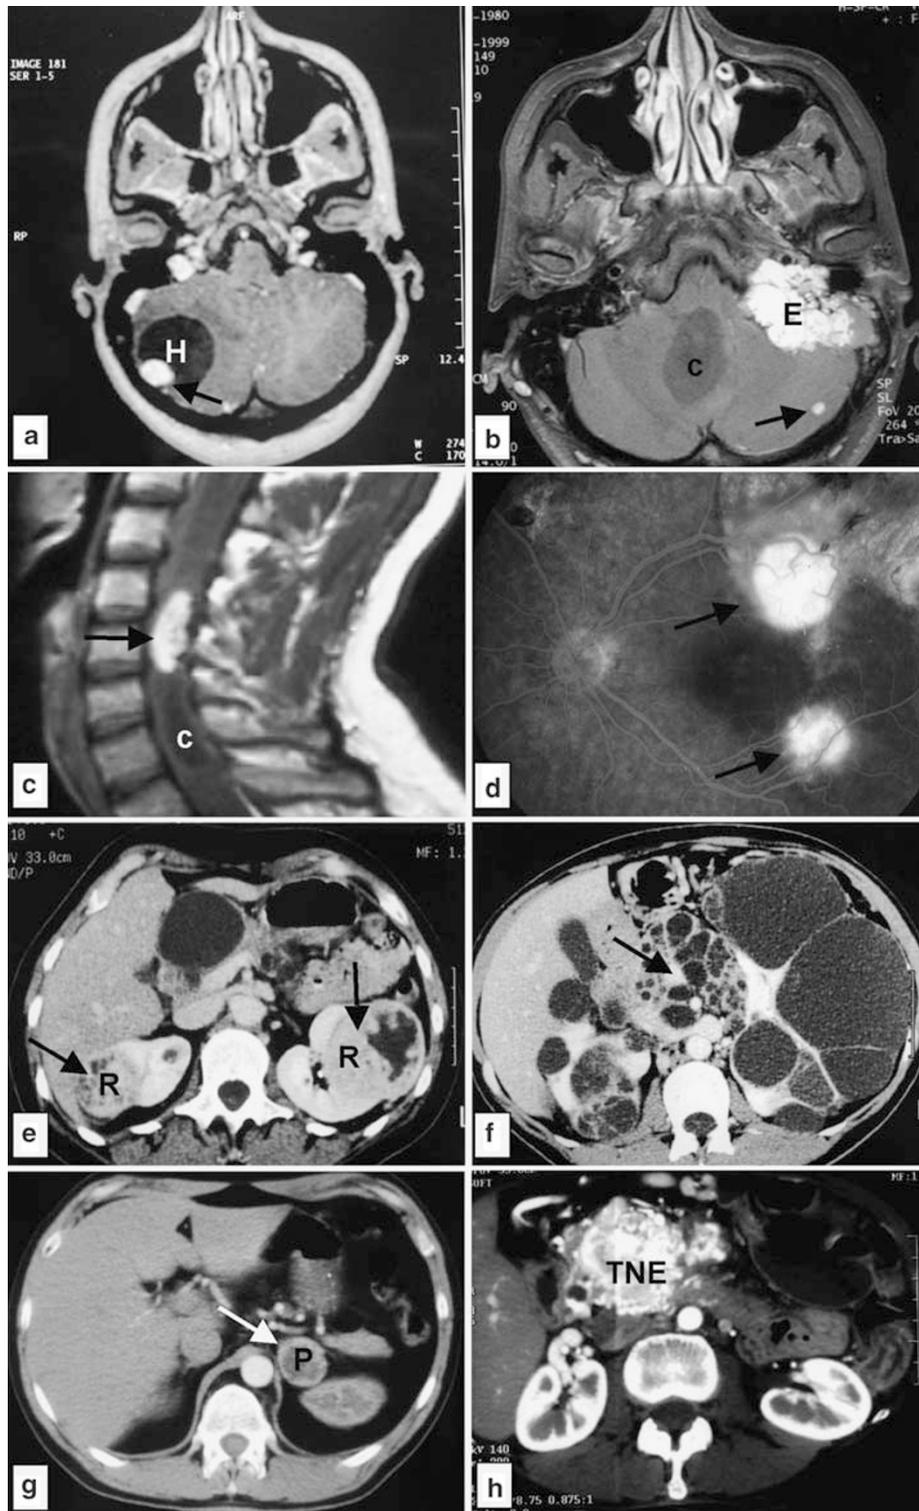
Main clinical manifestations of von Hippel-Lindau disease. (reprinted with permission from Richard S. von Hippel-Lindau disease: recent advances and therapeutic perspectives. *Exp Rev Anticancer Ther* 2003, 3: 215–233). (a) Right cerebellar haemangioblastoma with a large cyst in a 17 years old woman (T1-weighted contrast-enhanced MRI). (b) Endolymphatic sac tumor (E) in a 18 years old woman. Note also the presence of one haemangioblastoma cyst (c) and one quiescent cerebellar haemangioblastoma (arrow). (T1-weighted contrast-enhanced MRI). (c) Cervical spinal haemangioblastoma in a 35 yrs patient with a centromedullary cavitation below (c). (T1-weighted contrast-enhanced MRI). (d) Fluorescein angiography revealing two new large retinal haemangioblastomas (arrows) in an already previously laser-treated 44 years-old patient (courtesy of Professor Alain Gaudric). (e) Bilateral solid renal cell carcinoma (R) in a 38 yrs patient. CT scan. (f) Multiple bilateral cysts and cystic renal cell carcinomas in the kidneys of a 40 yrs patient. Note also the numerous pancreatic cysts (arrow). CT scan. (g) Left adrenal phaeochromocytoma (P) detected in an asymptomatic 24 yrs patient. CT scan. (h) Large pancreatic neuroendocrine tumor (TNE) in a 45 yrs patient. CT-scan (courtesy of Prof. Pascal Hammel).
